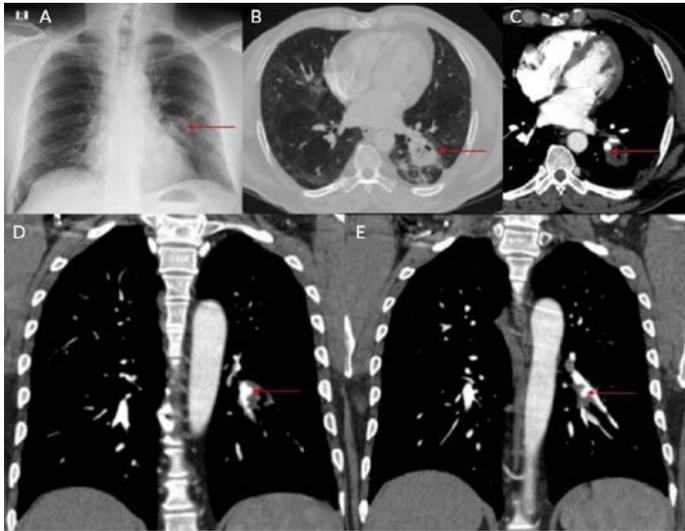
Amplatzer plug (Abbott) placement. (A) Chest X-ray posteroanterior view shows an area of cavitation with surrounding consolidation involving the left lower zone. (B) Contrast-enhanced computed tomography (CECT) chest with high-resolution CT window axial image shows cavitation with the surrounding area of consolidation involving the superior segment of the left lower lobe. (C), (D), and (E) CECT chest axial and coronal images showing an aneurysm involving the left descending pulmonary artery's superior and lateral segmental branches.
